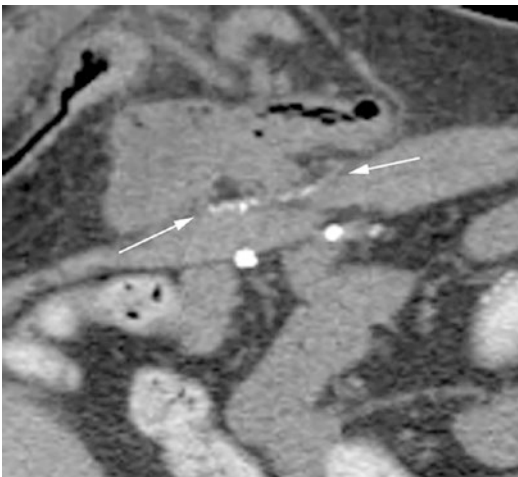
Magnified CT imaging of a recurrent parastomal hernia following stapled transabdominal ostomy reinforcement with retromuscular mesh (STORRM). A circular ring of staples (arrows) can be seen at the level of the anterior rectus fascia as the result of using an EEA stapler to fixate the mesh at this level
